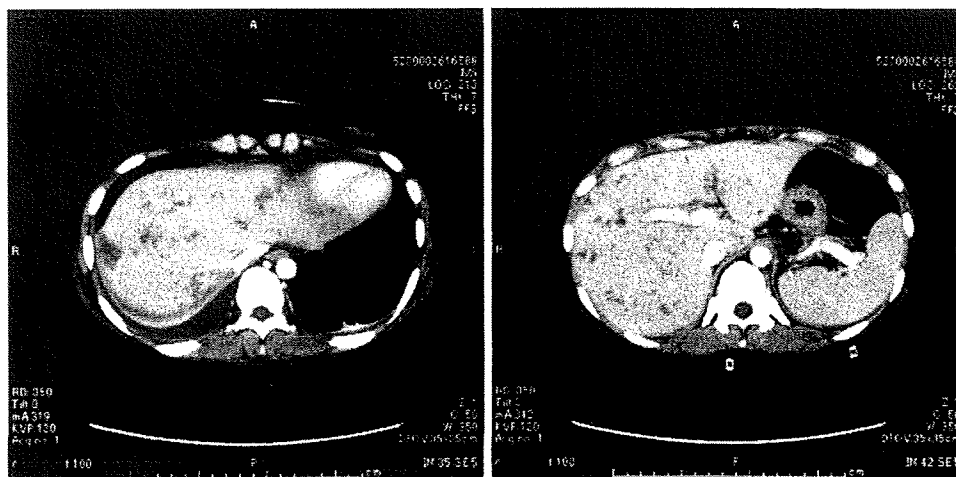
Computed tomography scan of the upper abdomen, showing multifocal hypodense lesions in the liver and right pleural effusion.
